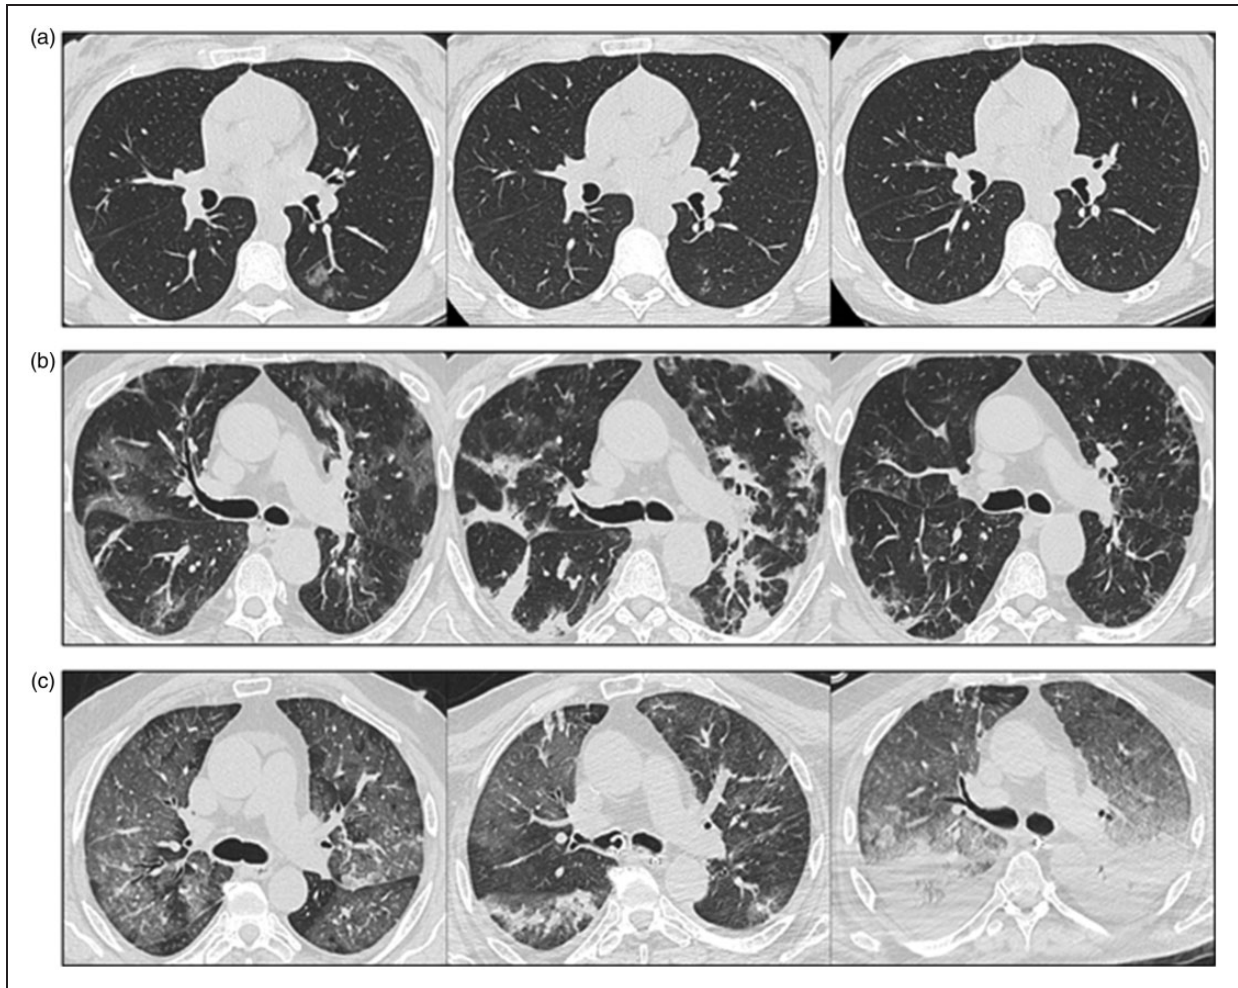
Serial high-resolution computed tomography (HRCT) images of three patients with a confirmed infection by SARS-CoV-2, showing different possible evolutions of lung involvement.
